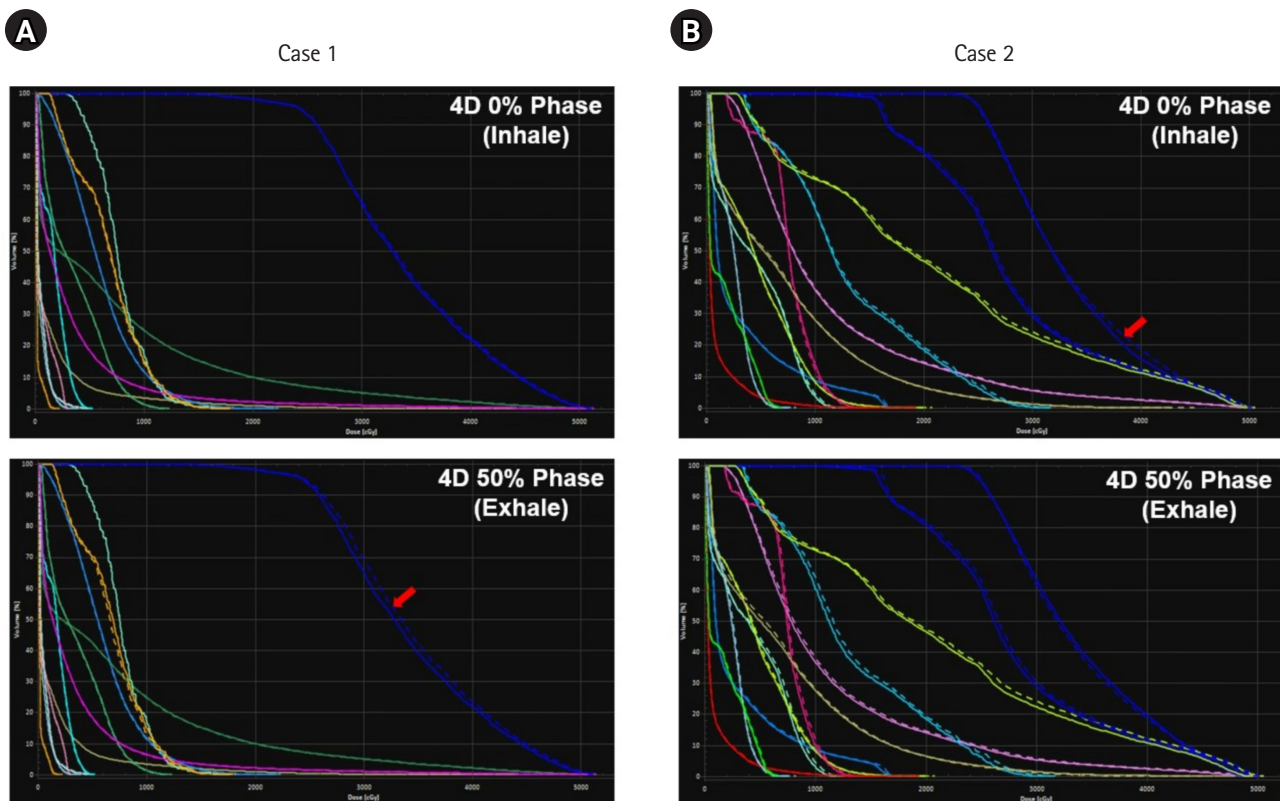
Dose volume histograms from the dose recalculated on the inhale (top) and exhale (bottom) phases of the four-dimensional (4D) computed tomography images investigating the degree of dosimetry impact from the respiratory motion: (A) case 1 and (B) case 2.
